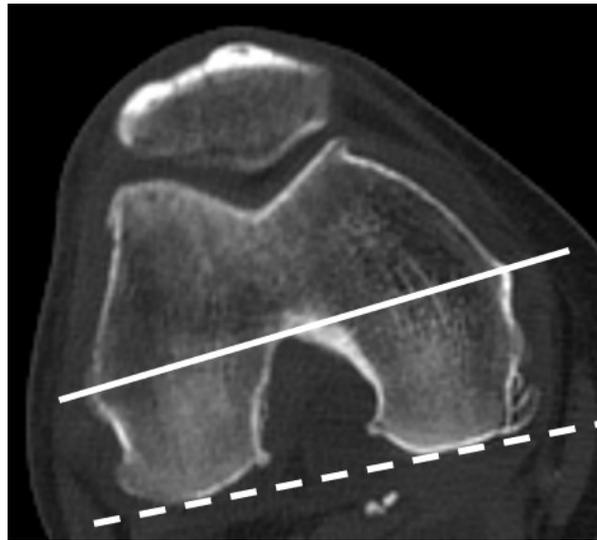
Computed tomographic scan of the axial view of the distal femur.
